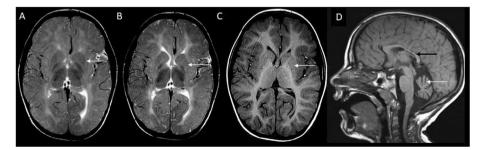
Hypomyelination with atrophy of the basal ganglia and cerebellum (HABC): Axial T2 images show diffuse hypomyelination along with small volume putamen. Subsequent MRI after one year shows no improvement in myelination but interval progressive volume loss of putamen. This is also evident on T1 axial image. T1 sagittal image (D) shows significant vermian atrophy as well as callosal thinning.
